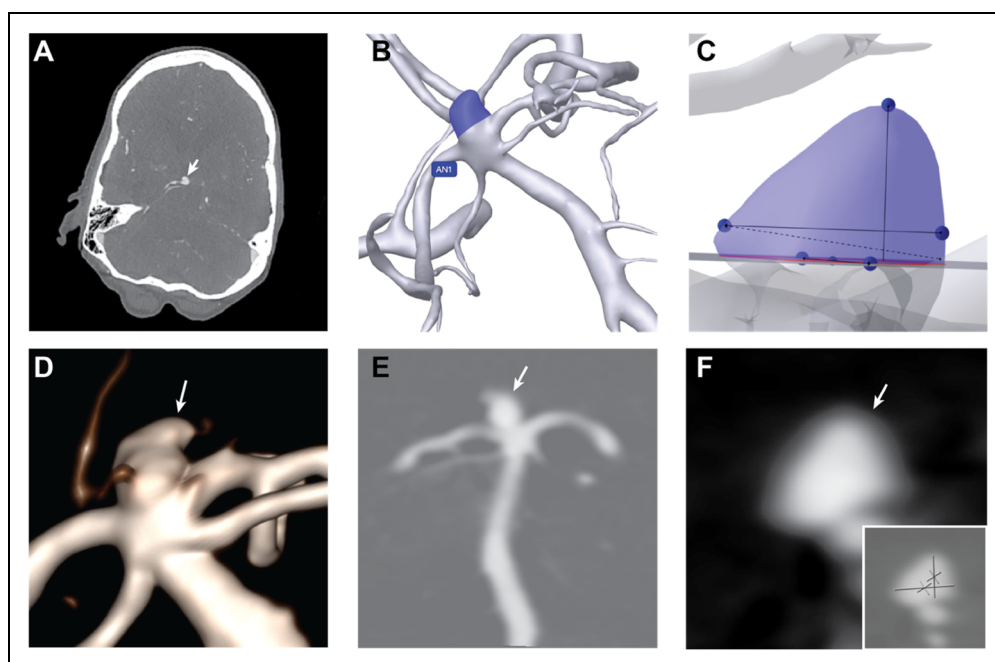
Representative case from a patient with a ruptured basilar artery aneurysm. A 6.3 mm aneurysm arising from the basilar artery terminus is shown on CTA source images (A, arrow). RAPID Aneurysm correctly identified this aneurysm (B, purple shading) and automatically provided size measurements (C). 3D-DSA images (D-F) demonstrate the aneurysm on volumetric images (D, arrow) and 2D images in the anteroposterior (E, arrow) and lateral oblique (F, arrow) views. Reference standard measurements were derived from the 3D-DSA data (F, inset) and showed an excellent agreement with those generated by RAPID Aneurysm.
